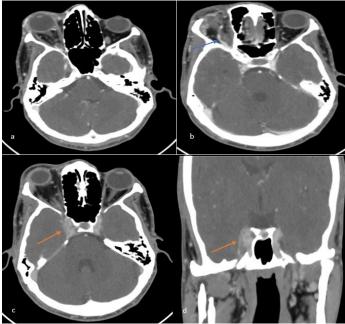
Axial (a, b, c) and coronal (d) CT images in parenchymal window showing grade III right exophthalmos with preserved globe morphology (a), dilated and early-enhancing superior ophthalmic vein (b; blue arrow), bulging and heterogeneous right cavernous sinus with convex lateral border (c, d; orange arrow), and infiltration of intra-/extraconal orbital fat as well as preseptal and malar soft tissues, without evidence of collection or abscess
